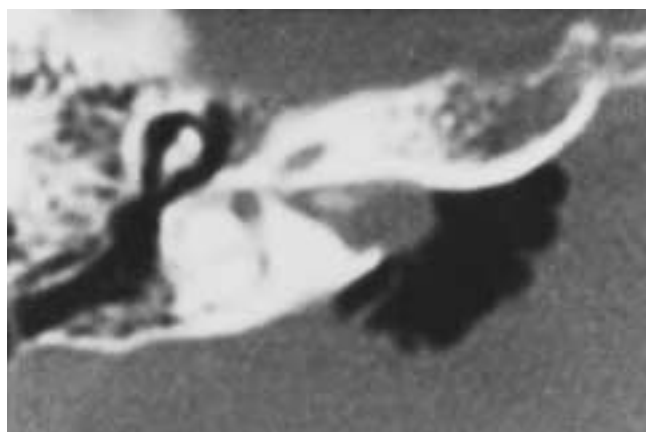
IAC vascular tumor. Gas CT cisternogram. Note the intratumoral bone spicule seen in some vascular tumors. (From Lo WWM, Horn HR, Carberry JN, et al. Intratemporal vascular tumors: evaluation with CT. *Radiology* 1986;159:181–185.)
